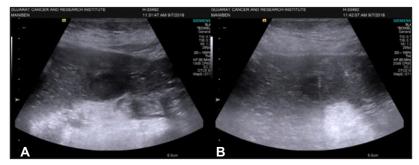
A) Well defined hypoechoic lesion in left lobe of liver seen on ultrasound image.
